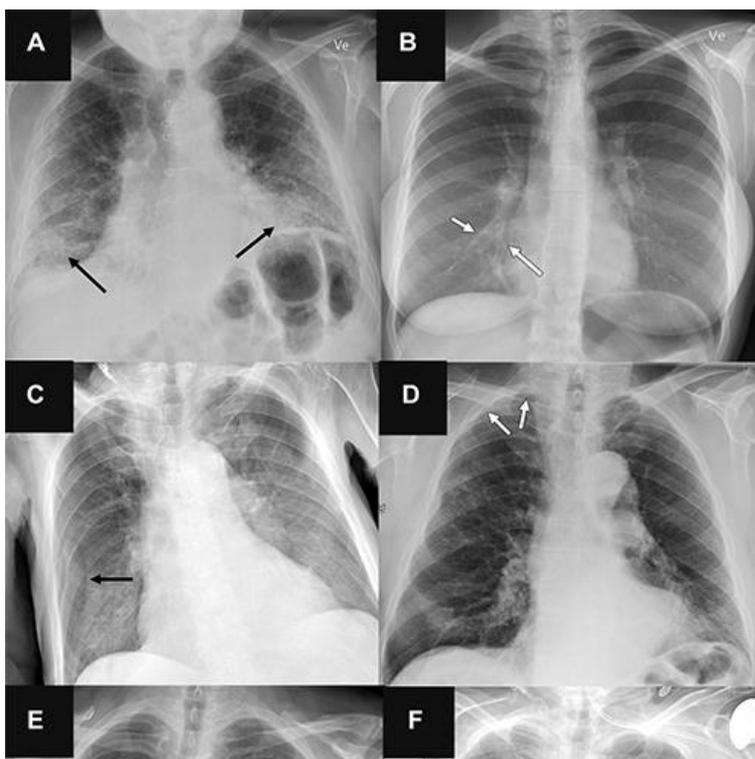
Representative chest radiographs in six patients show (A, C, E) false-positive findings and (B, D, F) false-negative findings as identified by the artificial intelligence (AI) tools [59].
